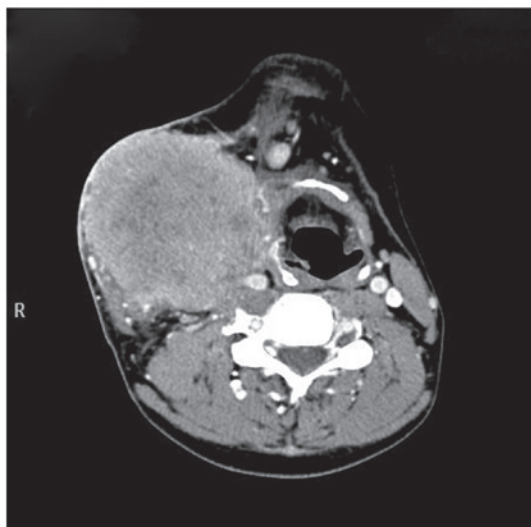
Computed tomography results indicating the presence of a giant mass without a clear boundary separating the mass from the carotid artery.
